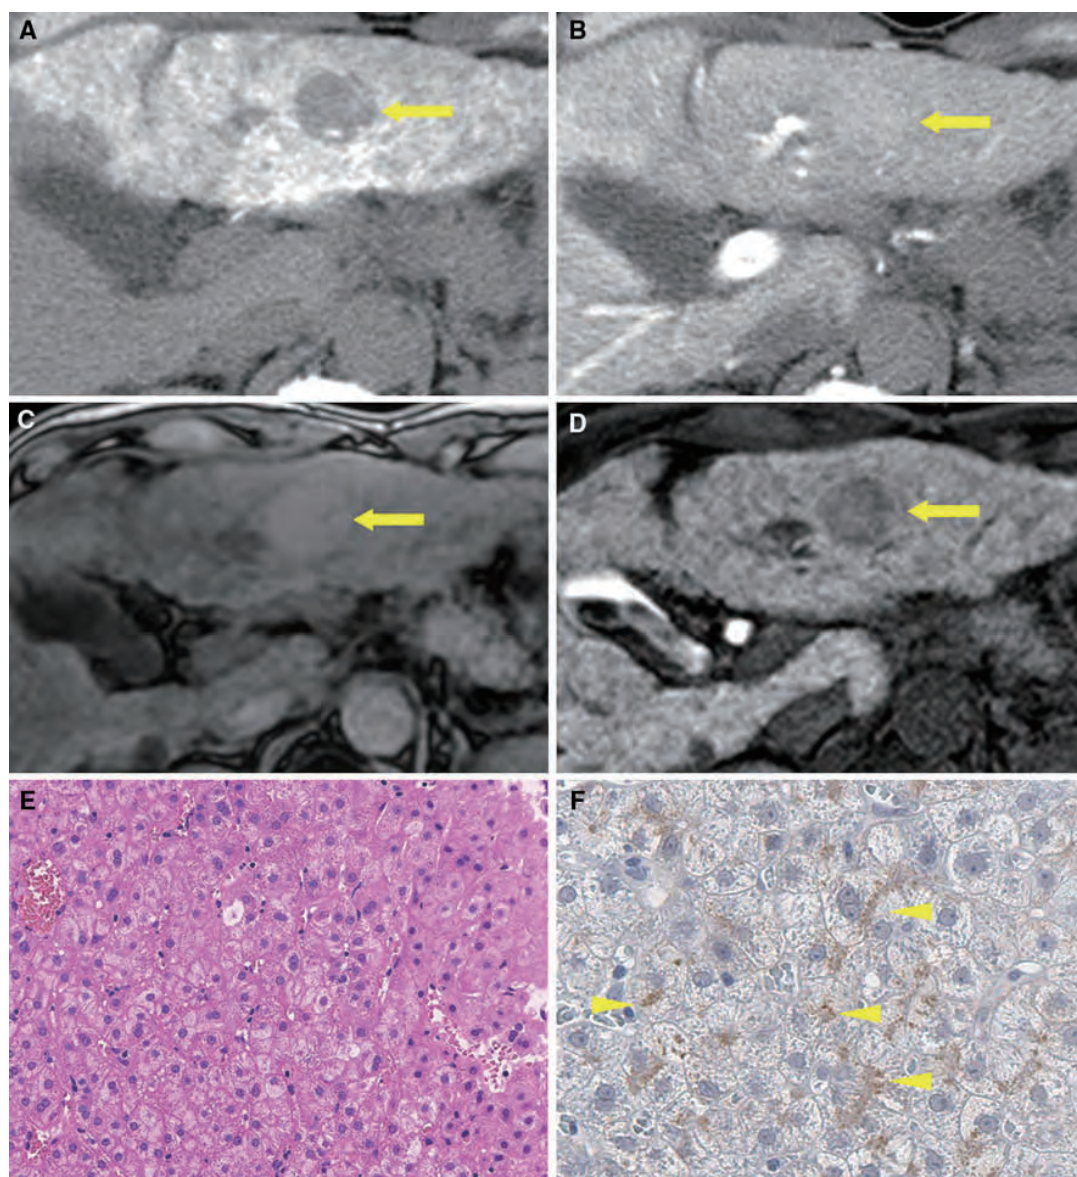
Case presentation of a 59-year-old man with well-differentiated HCC. a The tumor showed hypovascularity on CTHA (arrow). b The tumor showed slight hypervascularity on CTAP (arrow). c Pre-contrast T1-weighted image showed slight high intensity (arrow). d Image 20 min after Gd-EOB-DTPA bolus injection. The
